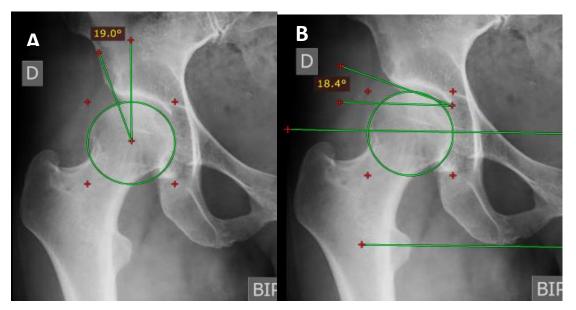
detailed radiograph of right hip in AP view of the pelvis showing; A. LCE angle 19° , B. acetabular index angle 18.4°
